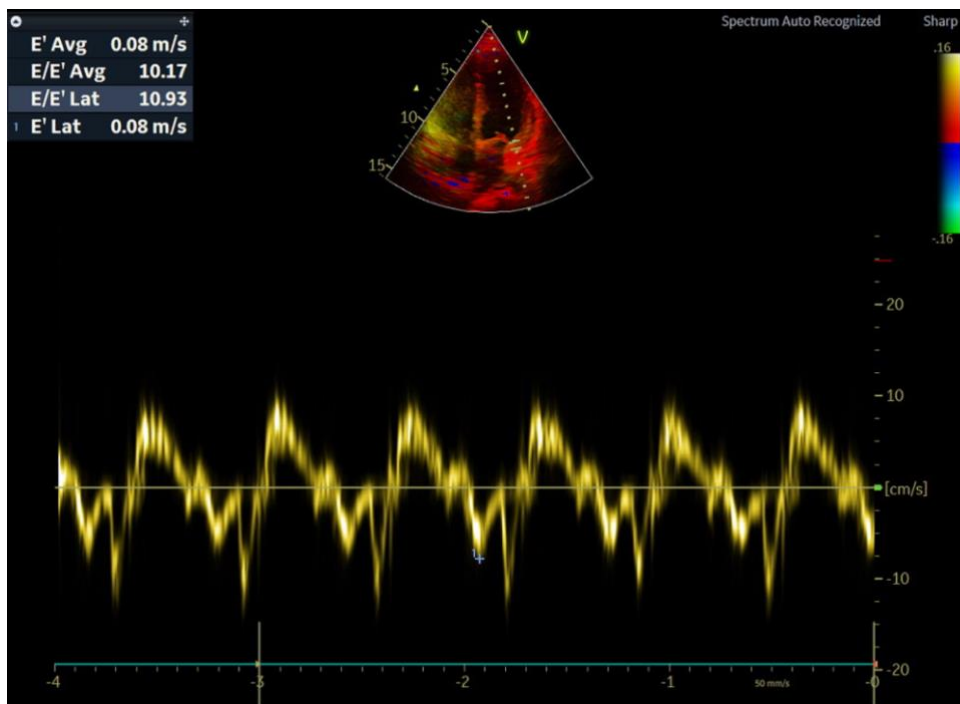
E/lateral e' reading using pulsed wave tissue doppler in 2D ECHO (2386 × 1769 cm: 600 dpi).
